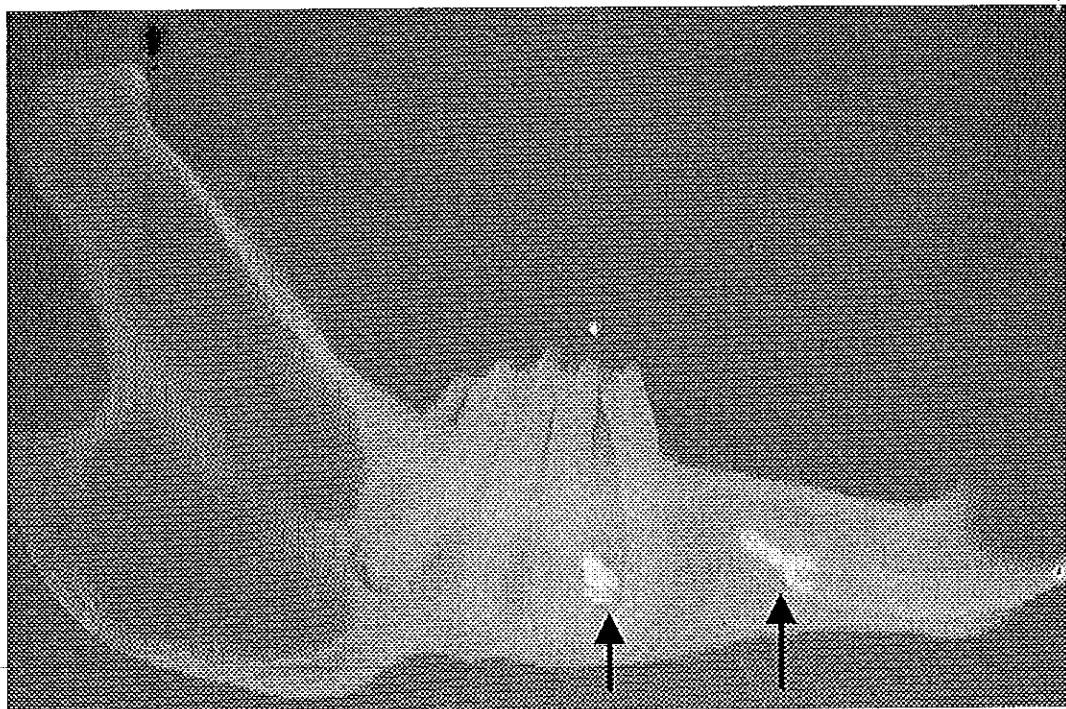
Lateral hemimandibular film at 6 months after completion of distraction, noted the definite similarity of the radiographic structure both in outer cortical layer and inner medullary cavity of the expanded gap demonstrated between the two marked screws. (arrows)
